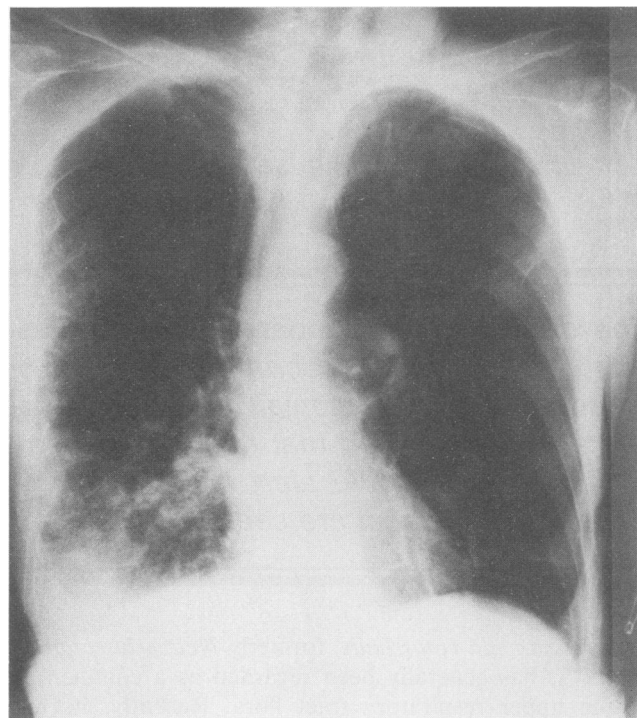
Chest roentgenogram of patient 4 showing a right lower lobe infiltrate.
